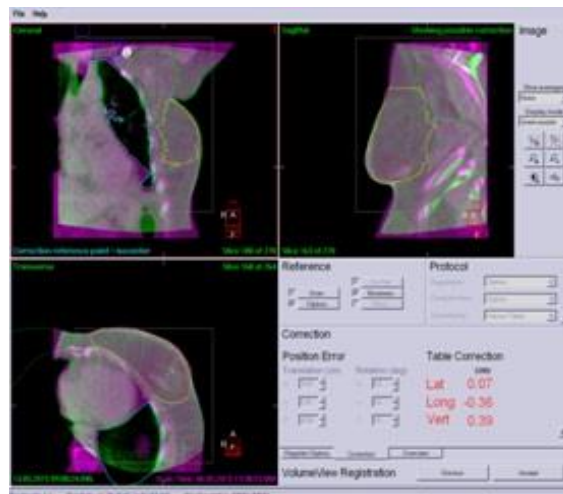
XVI 4.5 CBCT Scan
